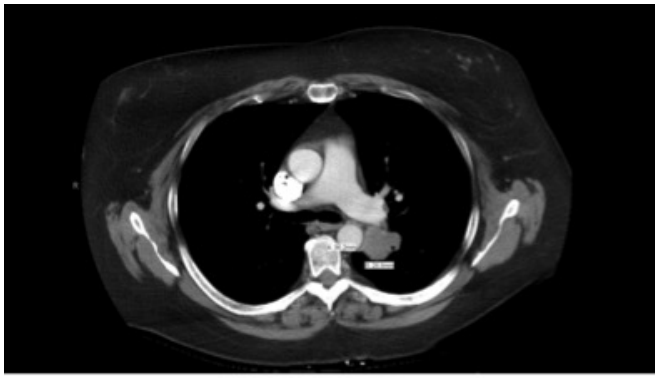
Patient 1, CT scan with left infrahilar mass.
